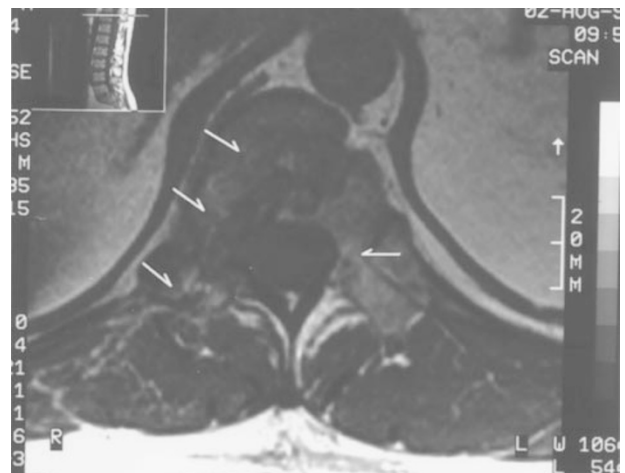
Lumbar spine MRI at T11 level, arrows pointing to the path left by a projectile and to an empty spinal canal
